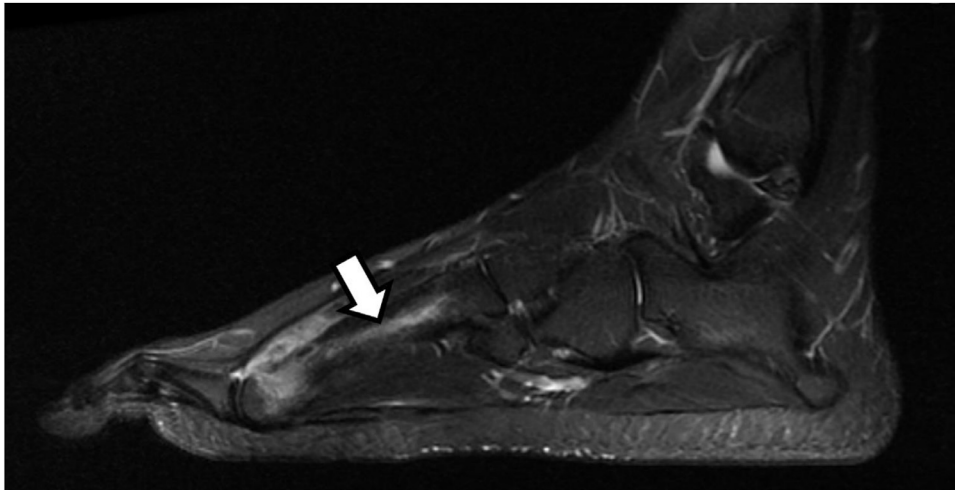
Sagittal T1 short tau inversion recovery (STIR) sequence of MRI scan of the left foot. Edema of cancellous bone (arrow) is clearly visible as a diffuse hyperintensity along the diaphyseal portion of third metatarsal.
